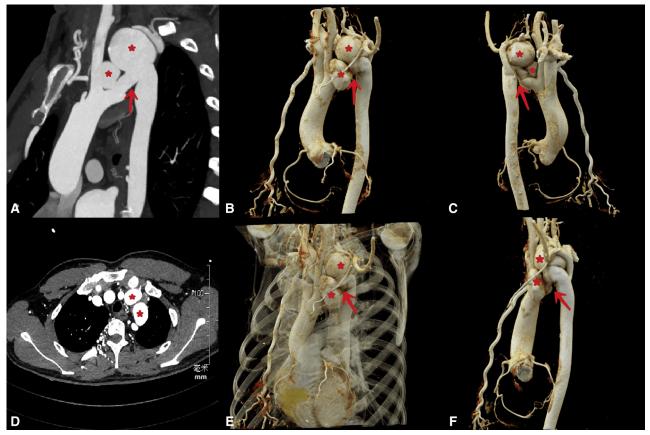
The preoperative aortic CTA and transthoracic echocardiography. The preoperative aortic CTA (A-F) showed the anatomical malformation of aortic arch including cervical aortic arch, coarctation of aortic arch (*red arrows*) and 2 aortic arch aneurysms (*red asterisks*). *CTA*, Computed tomography angiography.
